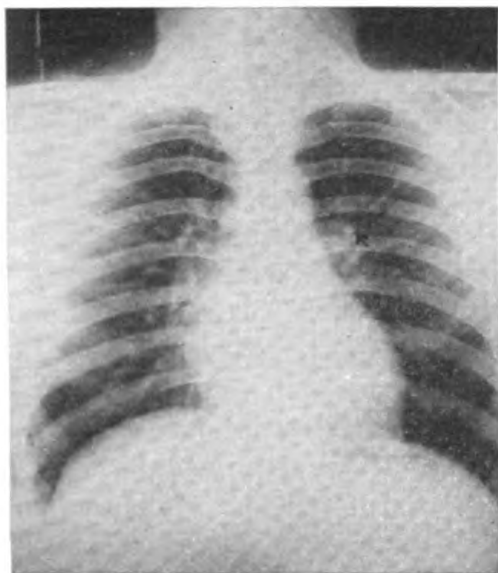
X-ray of chest in July 1940. Arrow indicates dense (calcific) shadow, considered to be a component of primary complex in left hilar zone (at upper border of fourth costochondral junction). Periphery and apices of lungs are clear.
